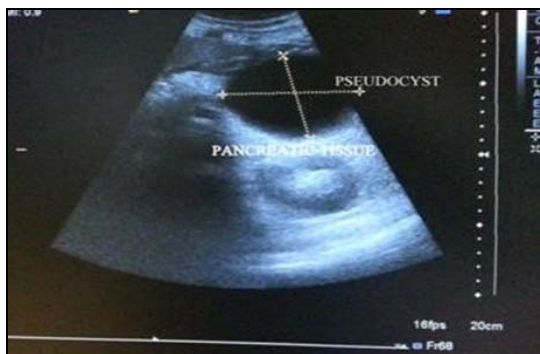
Ultrasonographic image of pseudocyst.
